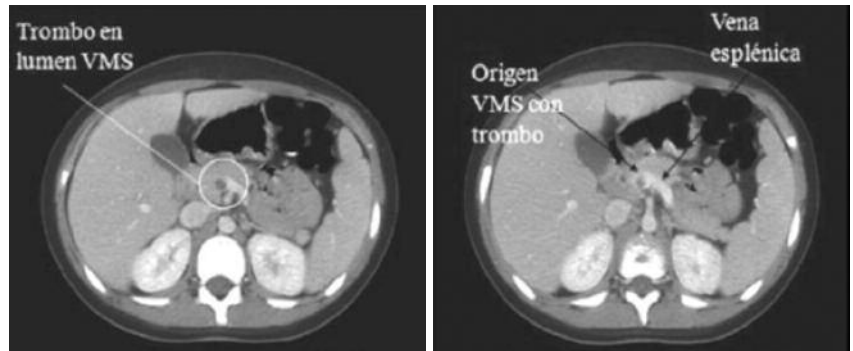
Abdominal computed tomography showing the presence of a thrombus in the superior mesenteric vein (SMV) (arrows).
